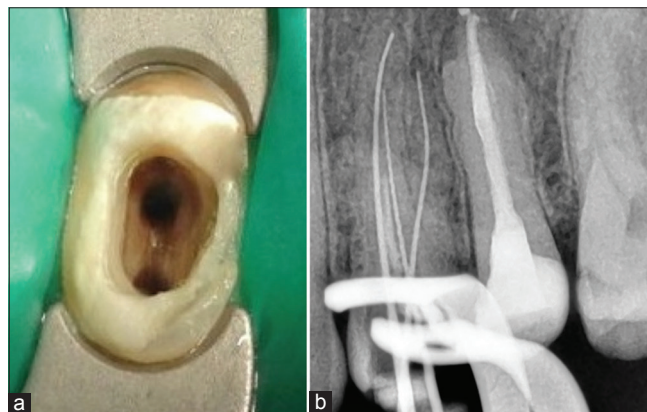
Maxillary left first premolar. (a) Photograph of access cavity. (b) Workinglength periapical radiograph
